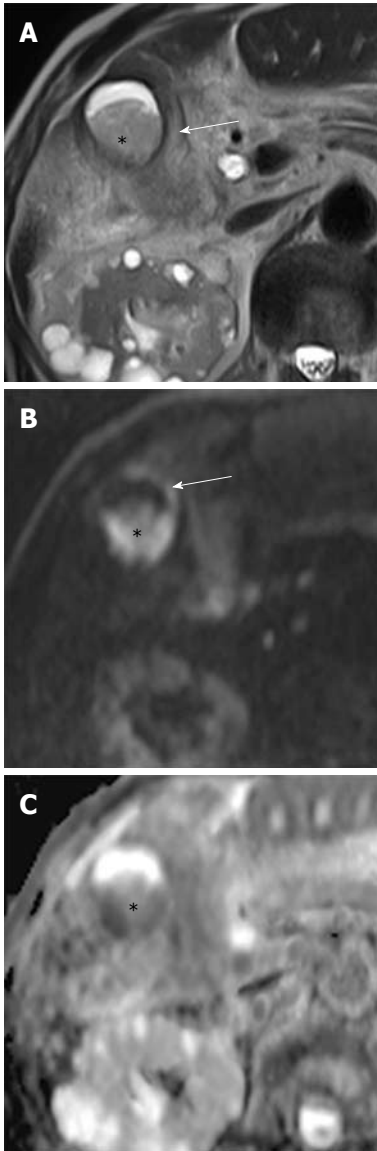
Gallbladder empyema in a 92-year-old man. A: Axial T2-weighted rapid acquisition relaxation enhancement image demonstrates a fluid-fluid level with low signal intensity in the dependent portion (asterisk) of an inflamed gallbladder (arrow); B: DWI at $b = 1000 \text{ s/mm}^2$ shows purulent bile with high signal intensity (asterisk), and diffuse, symmetric high signal intensity in the wall of the gallbladder (arrow); C: On an ADC map, pus in the dependent portion of the gallbladder appears with low signal intensity (asterisk) due to restriction of diffusion. Empyema was confirmed by aspiration of pus during percutaneous cholecystostomy. DWI: Diffusion-weighted magnetic resonance imaging; ADC: Apparent diffusion coefficient.
